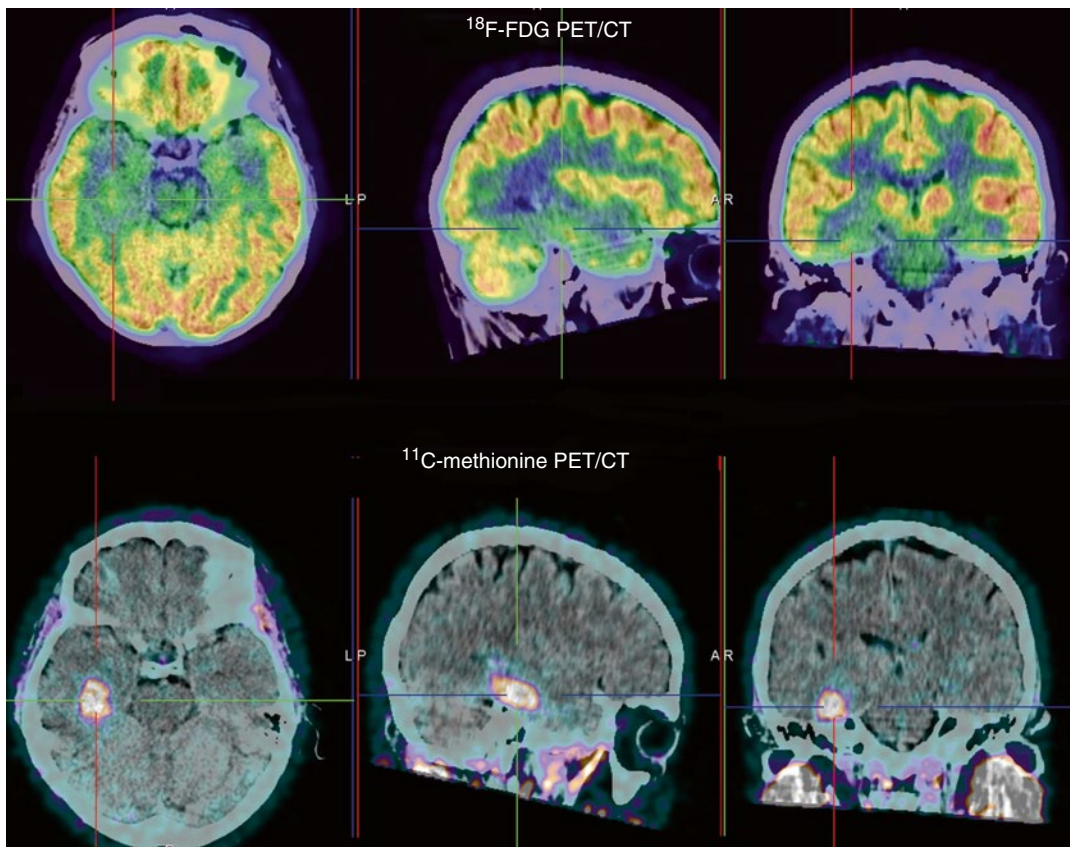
A glioblastoma at the right entorhinal cortex, hippocampus, and subiculum shows increased ^{11}C -methionine metabolism ($\text{SUV}_{\text{max}}=4.33$) but only minimally increased ^{18}F -FDG activity
